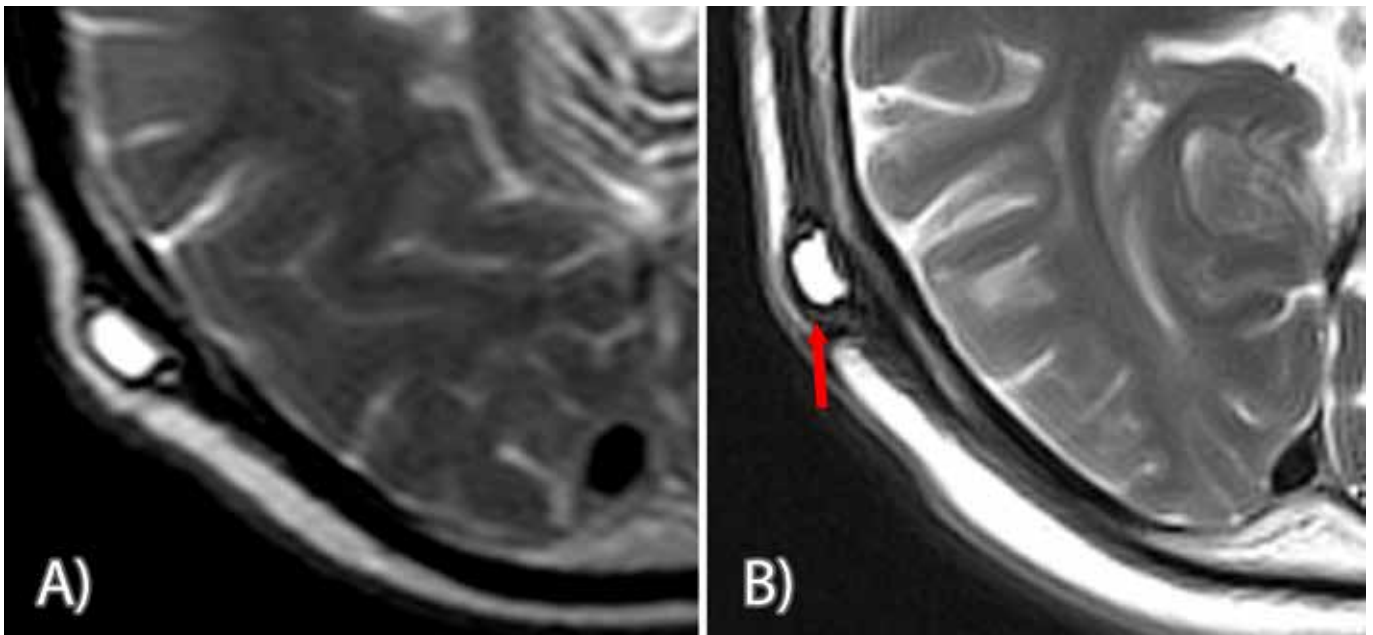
Preoperative (A) and postoperative (B) T2 sequence MRI demonstrating the PTFE layer over the shunt valve (red arrow)
